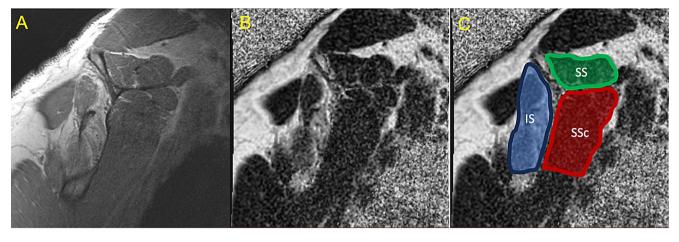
Sagittal (A) T1-weighted and (B) IDEAL MRI sequences demonstrating fatty infiltration of infraspinatus muscle. (C) Fat fraction measurements of the supraspinatus, infraspinatus, and subscapularis
